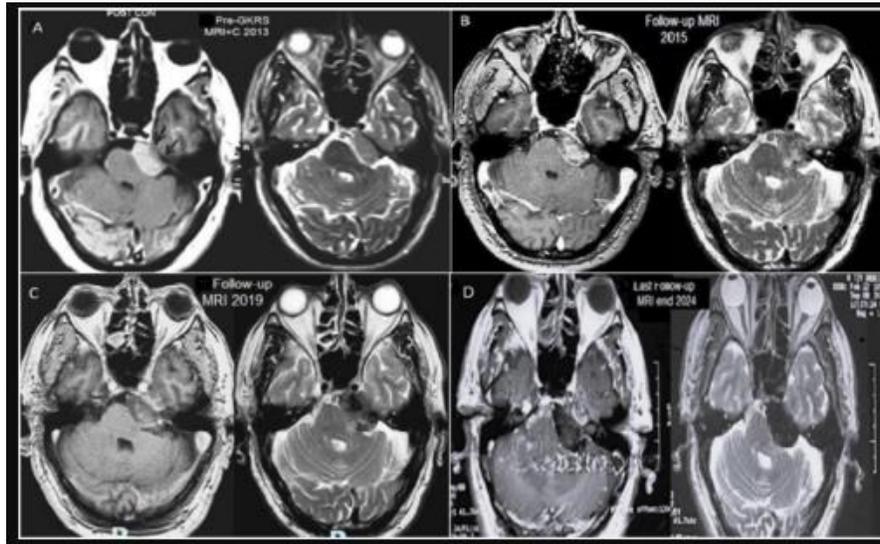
Serial MRI of GKRS treated left cerebellopontine angle meningioma;
